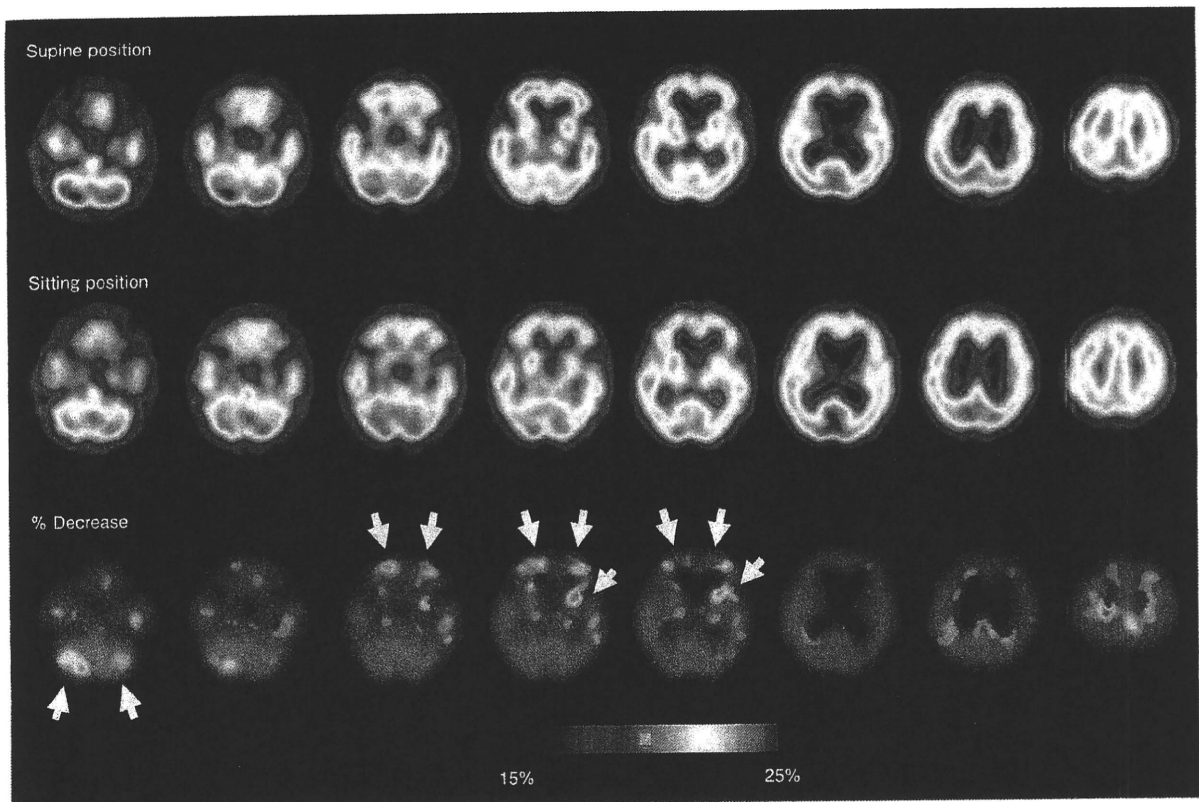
^{99m}Tc -ECD SPECT images.
